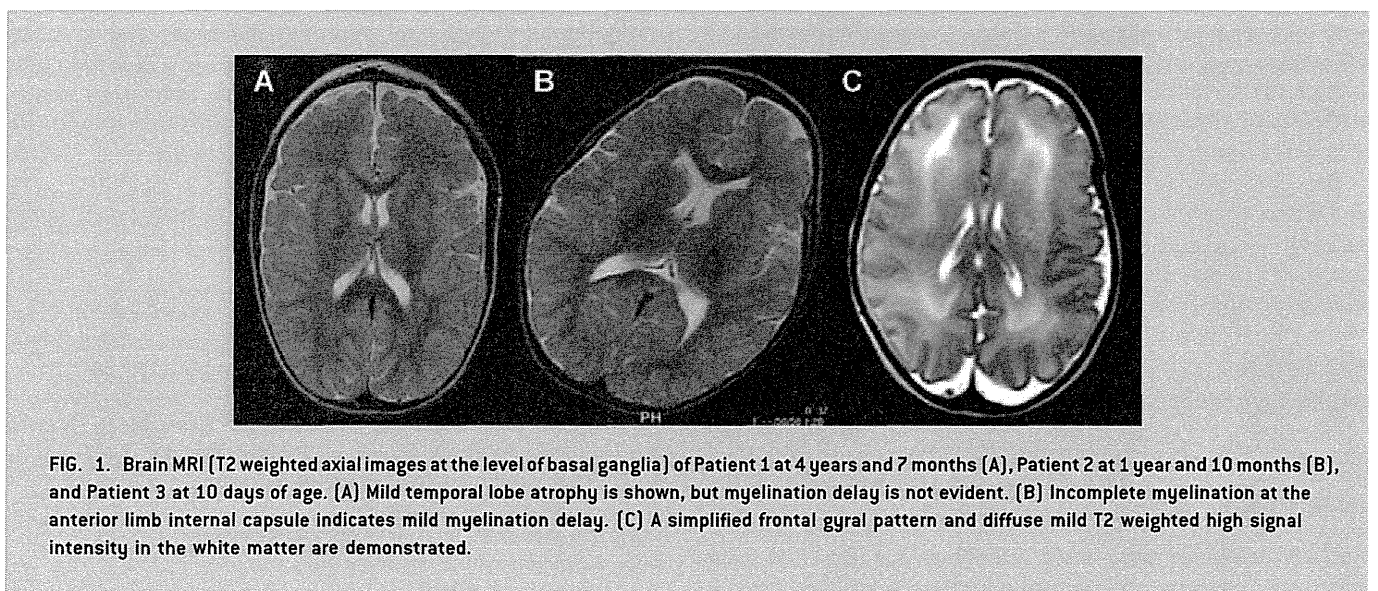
Brain MRI (T2 weighted axial images at the level of basal ganglia) of Patient 1 at 4 years and 7 months (A), Patient 2 at 1 year and 10 months (B), and Patient 3 at 10 days of age. (A) Mild temporal lobe atrophy is shown, but myelination delay is not evident. (B) Incomplete myelination at the anterior limb internal capsule indicates mild myelination delay. (C) A simplified frontal gyral pattern and diffuse mild T2 weighted high signal intensity in the white matter are demonstrated.
